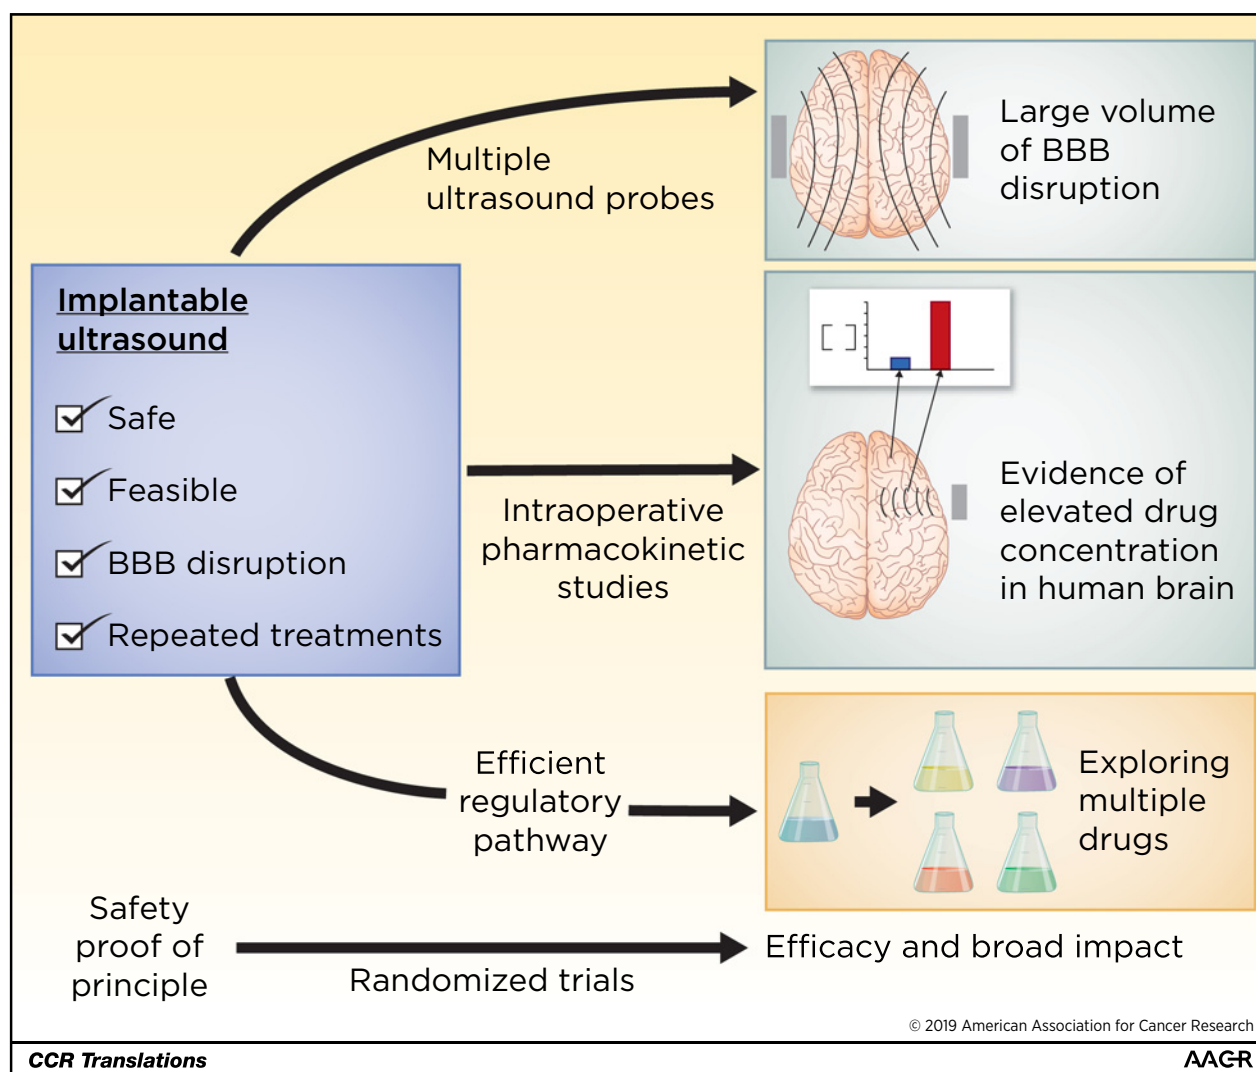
Next steps in development of implantable ultrasound. Boxes represent implantable ultrasound device.
